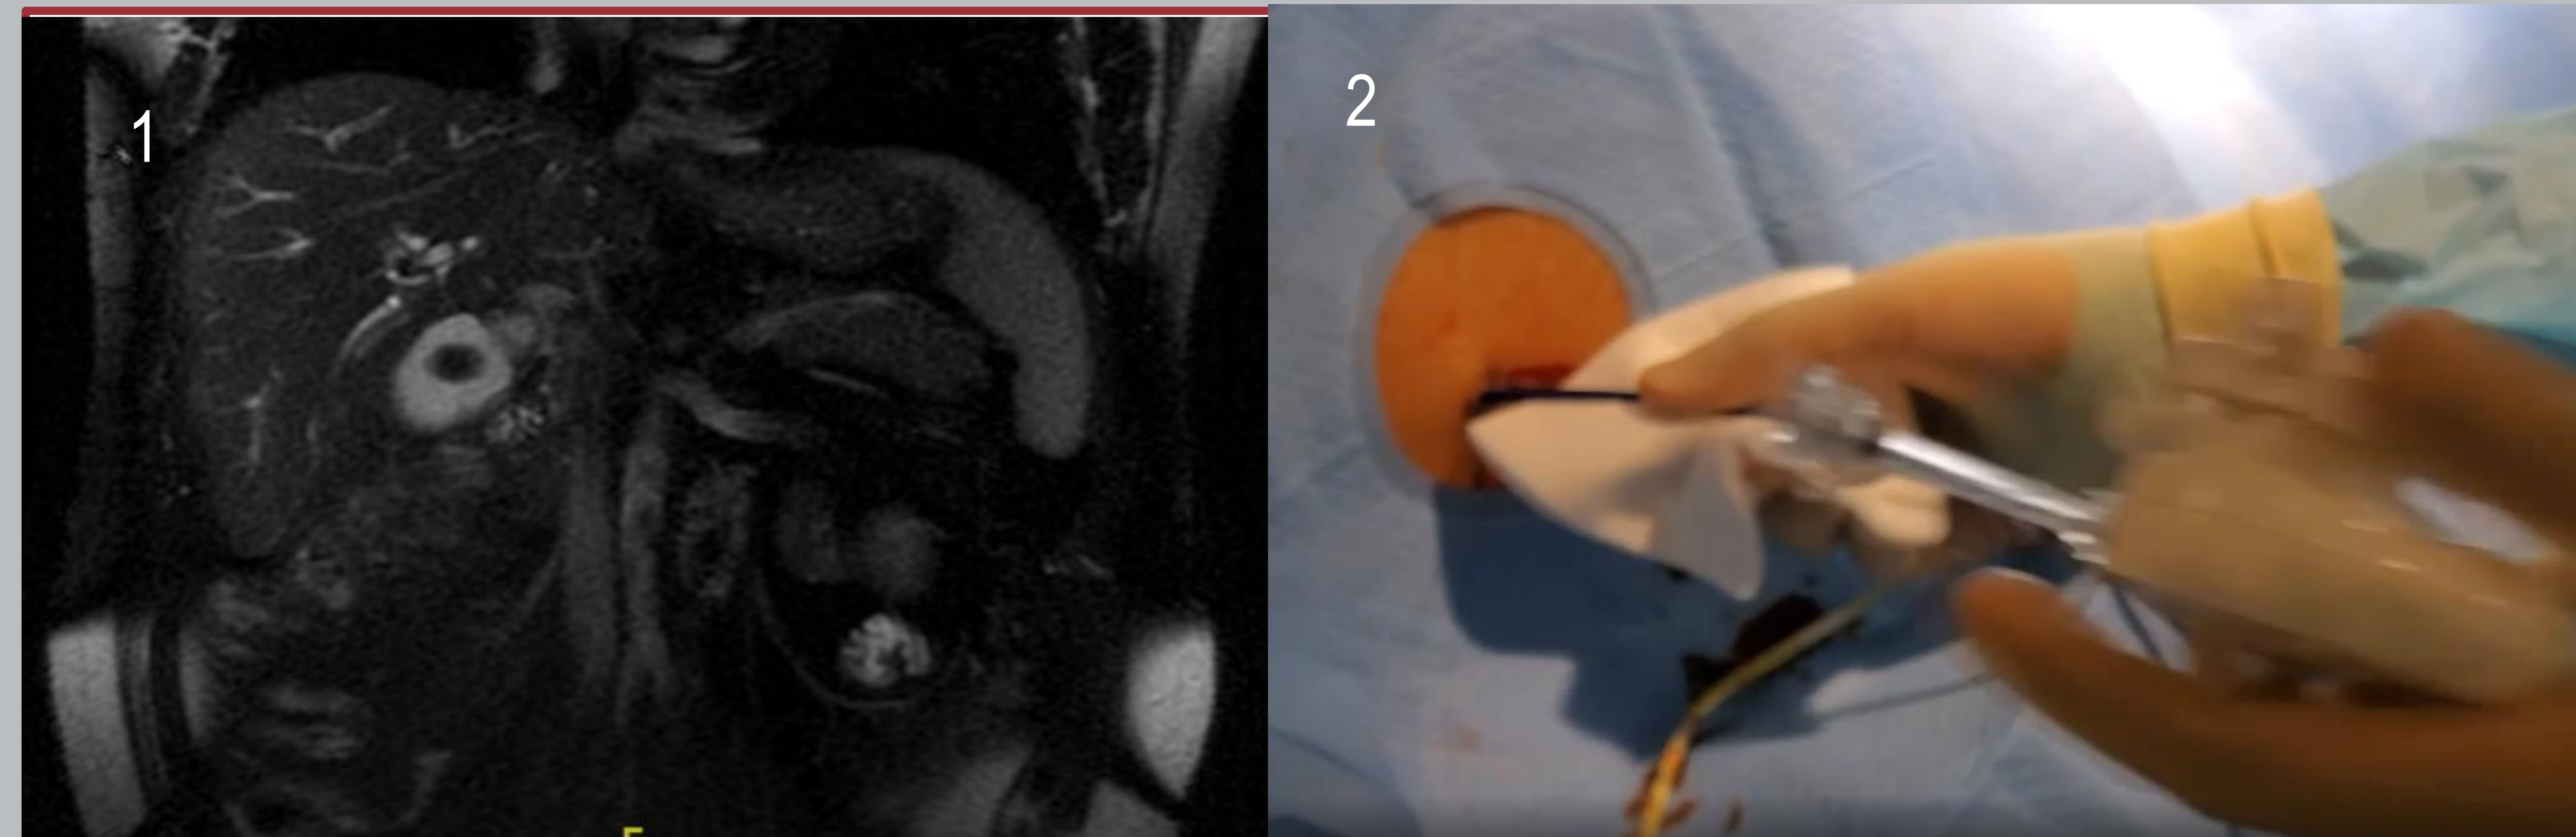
MRI Abdomen with MRCP with large gallstones, gallbladder neck, cystic duct, and proximal common bile duct thickening and enhancement and severe segmental narrowing of the affected proximal common bile duct resulting in moderately severe diffuse biliary dilatation proximally. Figure 2- Insertion of PTCS via the percutaneous transhepatic drain tract Figure 3 Frond like mass distal to the bifurcation of common bile duct
